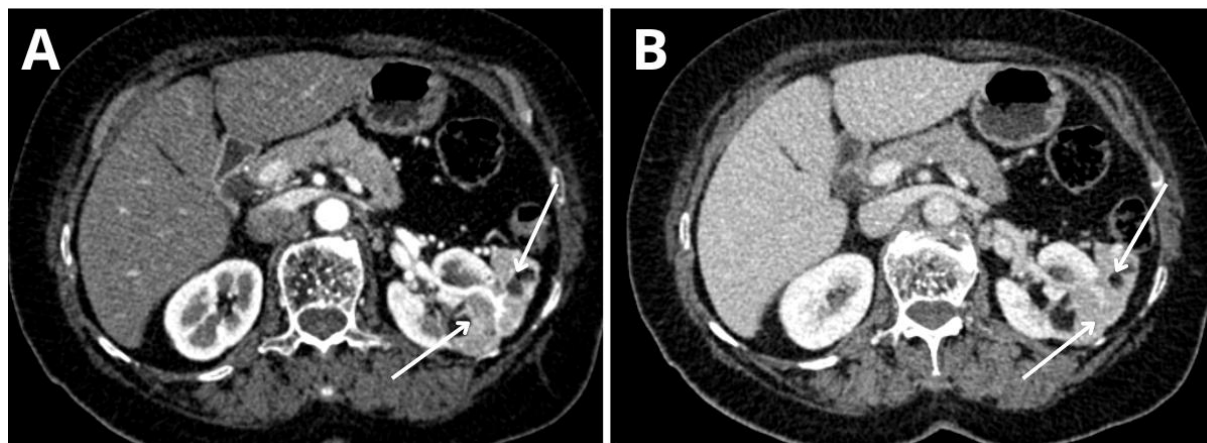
Axial arterial phase (A) and axial portal venous phase (B) sections of abdominal CT showing a hypervascular left renal mass containing a fatty contingent measuring 63x37mm related to an angiomyolipoma (white arrows).
